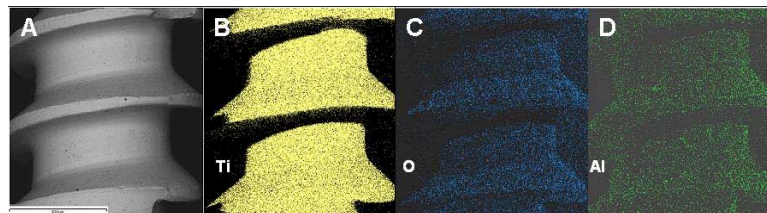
X-ray microanalysis (EDX) of the Aluminum oxide coated implant. A- SEM image of the implant. B, C and D- Scanning of the surface demonstrate the presence of titanium (B), oxygen (C) and aluminum (D) covering the surface.
